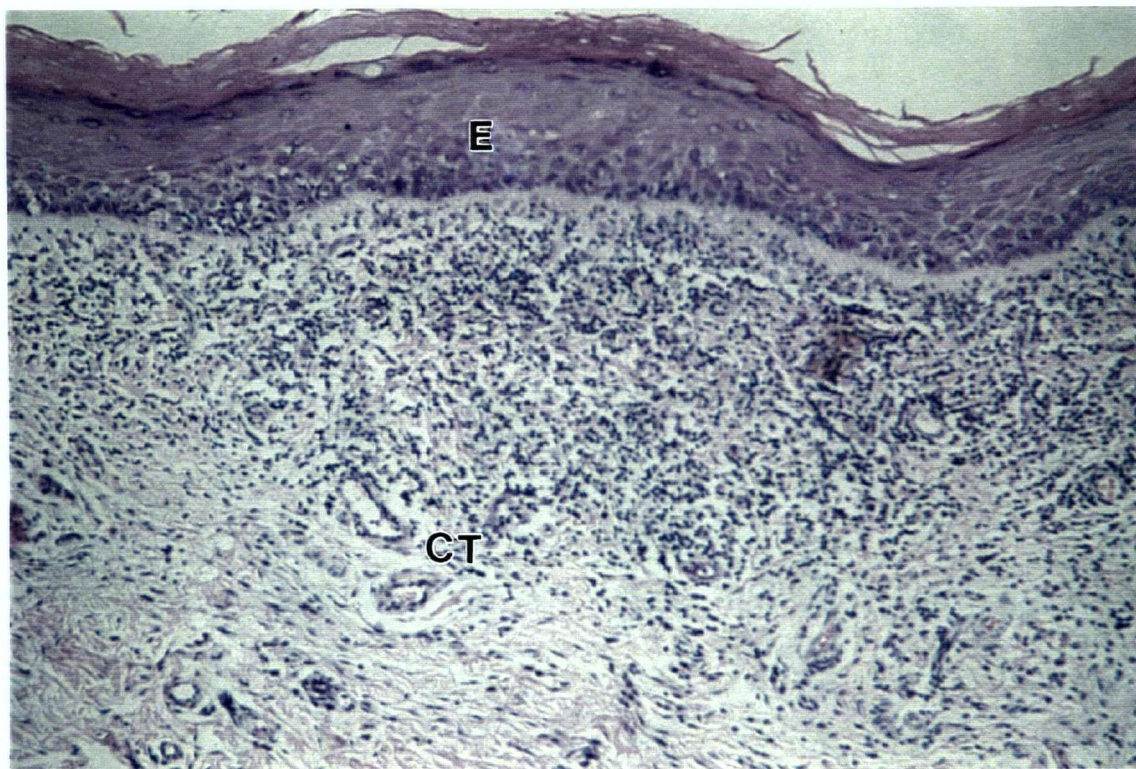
Oral lichen planus; E=Epithelium, CT=Connective tissue
